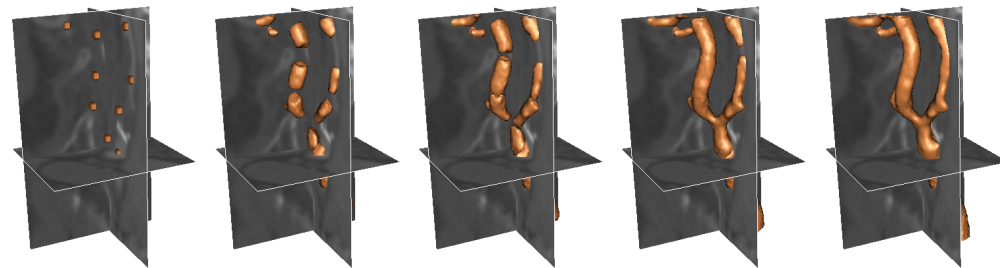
Segmentation of carotid artery from CT image dataset 6 (70x80x120) using GPF deformable model (CPU-time, 185s).
